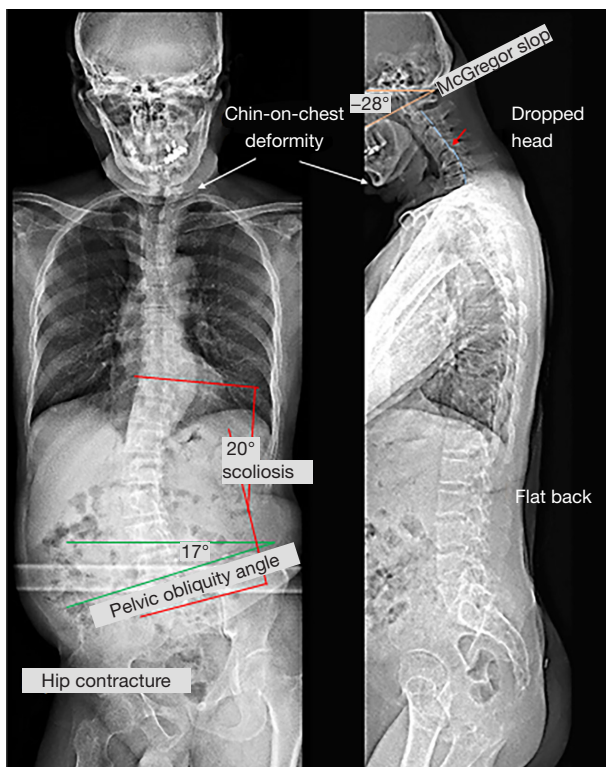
At initial presentation, coronal radiograph shows right pelvic drop, right hip contracture with abduction and a right thoracolumbar curvature with a 20° Cobb angle between T10 and L5. Lateral view reveals reverse cervical lordosis with anteroflexion deformity (white arrow), -28° McGregor slop, mild subluxation of C4 relative to C5 (red arrow), osteophytes in the lower cervical and lumbar spine, and interspace narrowing of the C3/C4, C5/6, C6/C7, C7/T1, and L4/5 levels. McGregor's line is a hypothetical line drawn between the hard palate and the most caudal point of the occipital curve.
